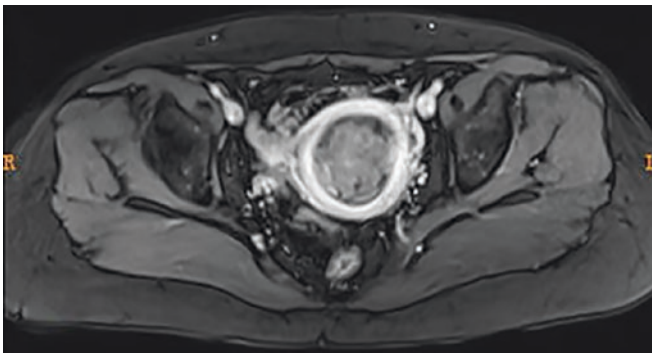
A 54-year-old woman with ECS. On DWI, the mass displayed relatively low signal on the corresponding ADC map
